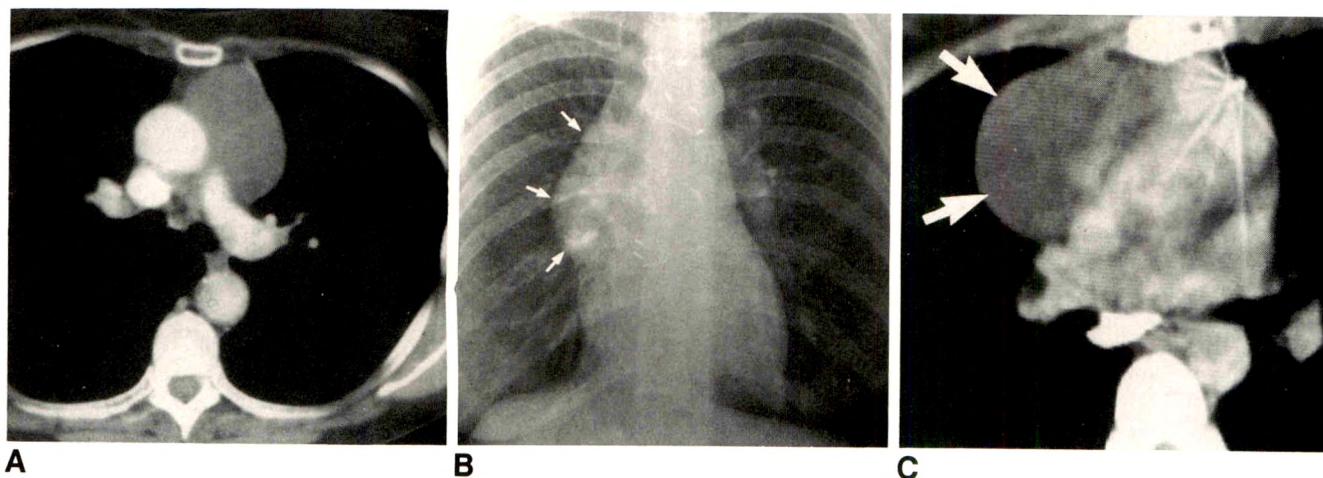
A, 72-year-old woman with anterior mediastinal mass of recent onset. Contrast-enhanced CT scan shows anterior mediastinal mass with low attenuation and density similar to that of water, typical of benign thymic cyst. Diagnosis was confirmed surgically.
